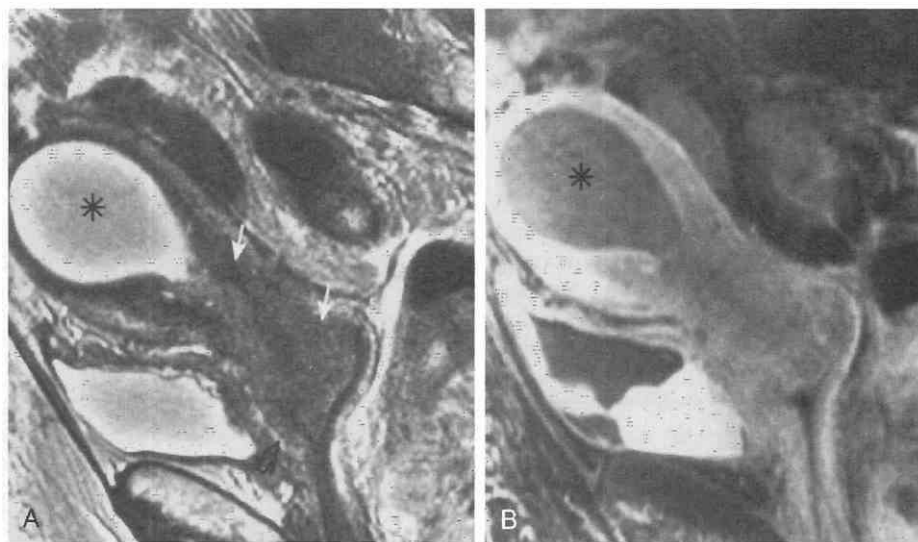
Obstructed uterus caused by endocervical adenocarcinoma. A, Sagittal T2-weighted, fast spin-echo (FSE) image (TR = 6000 msec, TE_{eff} = 119 msec) shows a hematoma (asterisk) caused by an irregular intermediate-signal-intensity tumor (white arrows) obstructing the end of the cervical canal. Because of tumor infiltration, the normal low signal intensity of the cervical stroma is entirely disrupted and the junctional zone in the low uterine segment is irregular and disrupted. The vaginal wall is irregularly thickened (open arrow). B, Sagittal gadolinium-enhanced image corresponds to the same level as in A. The endocervical canal tumor enhances, although not as much as the normal myometrium, and the hematoma (asterisk) does not enhance. The thickened enhancing tissue along the anterior vaginal wall indicates vaginal wall invasion. TE_{eff}, effective echo time.
